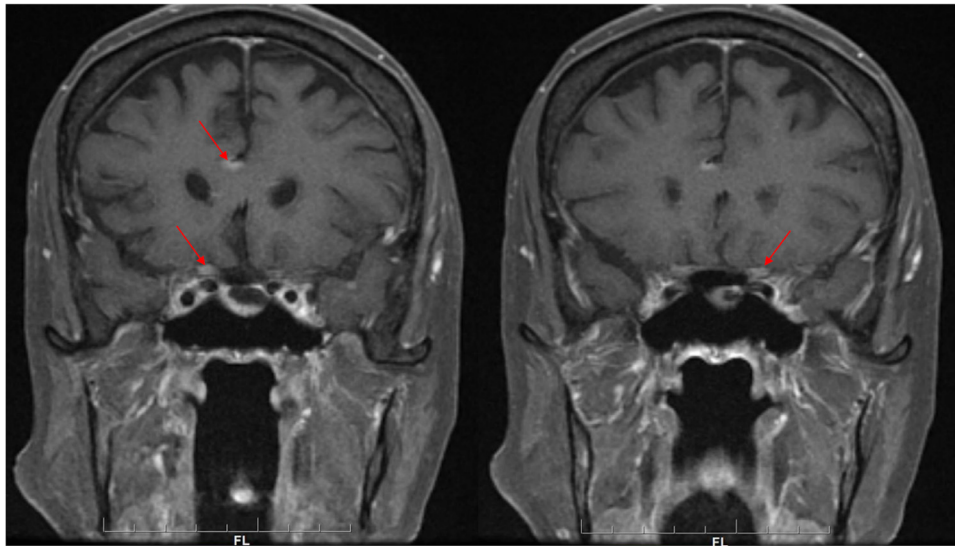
Magnetic resonance imaging of the brain and orbits with contrast after vision loss demonstrating areas of leptomeningeal enhancement (red arrows) including both optic nerves.
